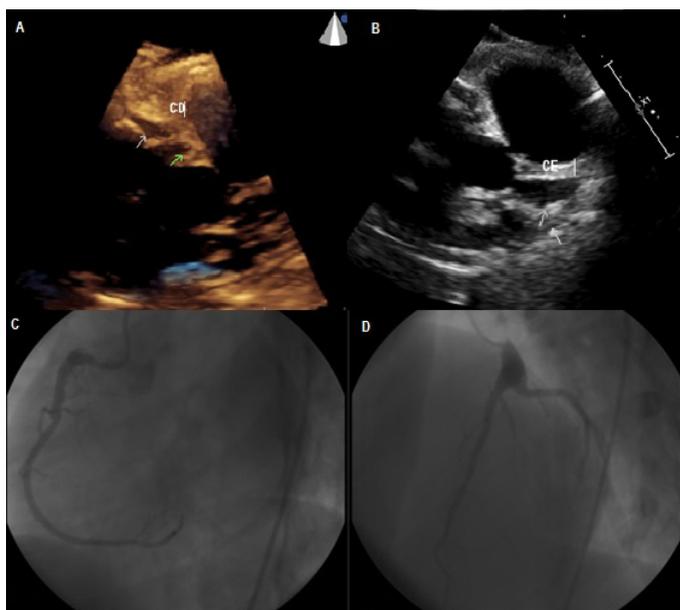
(A and B) Echocardiography: ejection fraction 68%; left atrium 35 mm; septum 8mm; posterior wall 8mm; left ventricular diastolic diameter 45mm; left ventricular systolic diameter 30 mm; PSAP 40 mmHg. Dilatation of left coronary artery (7 mm). Left ventricle with preserved systolic function and myocardial thickness, with no changes in segmental wall motion. (C and D) Cardiac catheterization (10/2013): coronary artery ectasia. Dominant coronary with 50% proximal, eccentric tubular lesion and coronary thrombosis; left coronary artery trunk with aneurysmatic dilatation at the distal third; anterior descending artery with ectasia at the proximal third, without obstructive lesions. Circumflex artery with proximal ectasia, without obstructive lesions.
